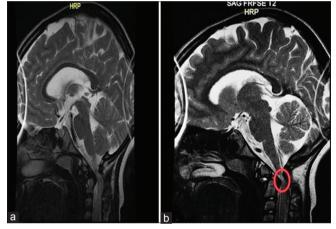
(a) Sagittal T2 magnetic resonance image (MRI) showing evidence of craniovertebral junction anomaly. (b) Sagittal T2 MRI showing significantly compressing the cervicomedullary junction and the upper cervical cord with evidence of focal myelomalacia (circle)
